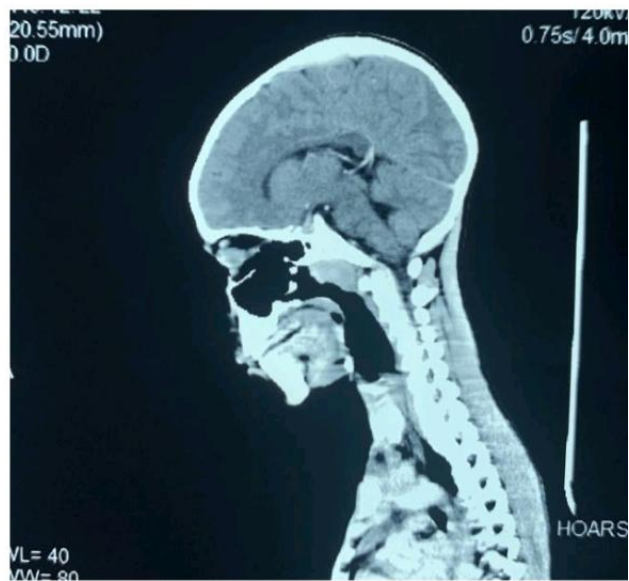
CT scan of the larynx and trachea revealed soft tissue mass in the glottic, and area of subglottic narrowing.
